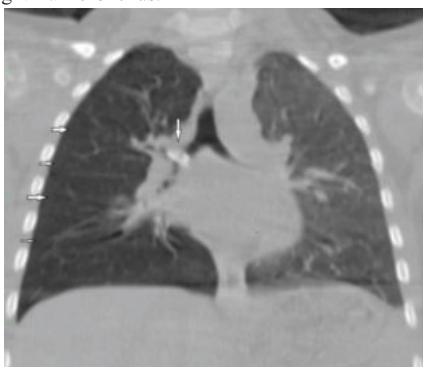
Three dimensional coronal reformatted CT image showing foreign body in right main bronchus (downward arrow) with postobstructive hyperinflation of right lung (rightward arrows).
